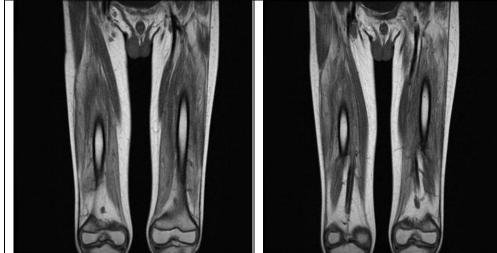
T1-weighted axial MRI showing extensive fatty infiltration in all thigh compartments, sparing sartorius and gracilis muscles.
